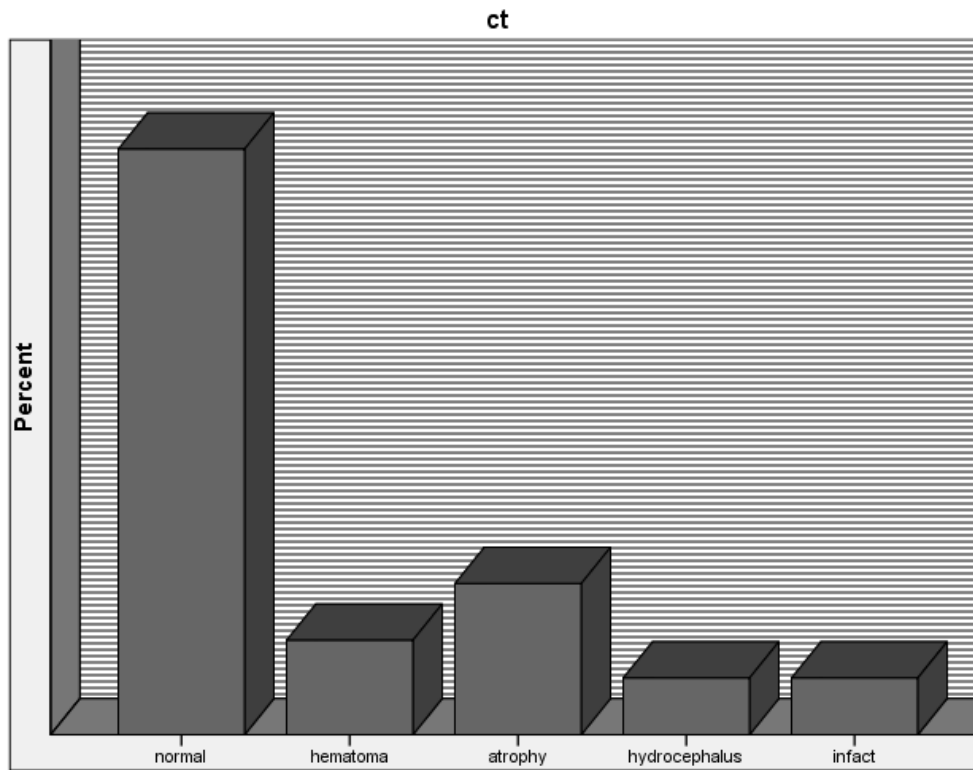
Shows the distribution of CT brain Findings
